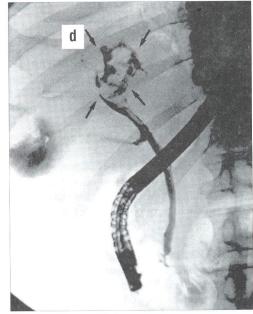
HCC in a 68-year-old cirrhotic patient. (a) A 3-cm lesion in the 8th segment. (b) Arterial phase CT scan two months after RFA; a necrotic area measuring more than 4cm is shown. Slight dilatation of the biliary tree is evident (white arrowheads). (c) Three months later MRI was performed for jaundice; the axial T2-weighted image shows the right biliary duct, which is ablated and nearly occluded by a solid neoplastic component (white arrowheads). (d) At the same time endoscopic cholangiography shows complete tumoral involvement of the biliary bifurcation and the intrahepatic tree (black arrows).
